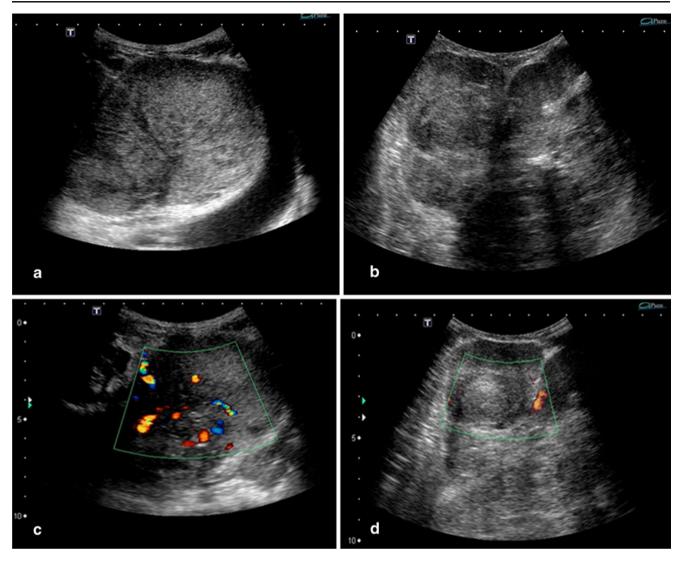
a & b Sonographic images showing STS in pelvic (a) and left abdominal wall (b). c & d show peripheral tumor perfusion on the color flow imaging
